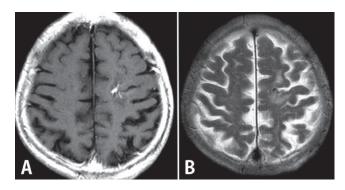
A case of asymptomatic developmental venous anomaly (DVA) with white matter abnormality observed on MRI. A 72-year-old woman underwent brain dock and a DVA was discovered incidentally. (A) Gadoliniumenhanced gradient-echo T_1 -weighted image showing DVA in the left frontal lobe. (B) T_2 -weighted image demonstrating high intensity area representing gliosis due to venous congestion within the territory of DVA.
